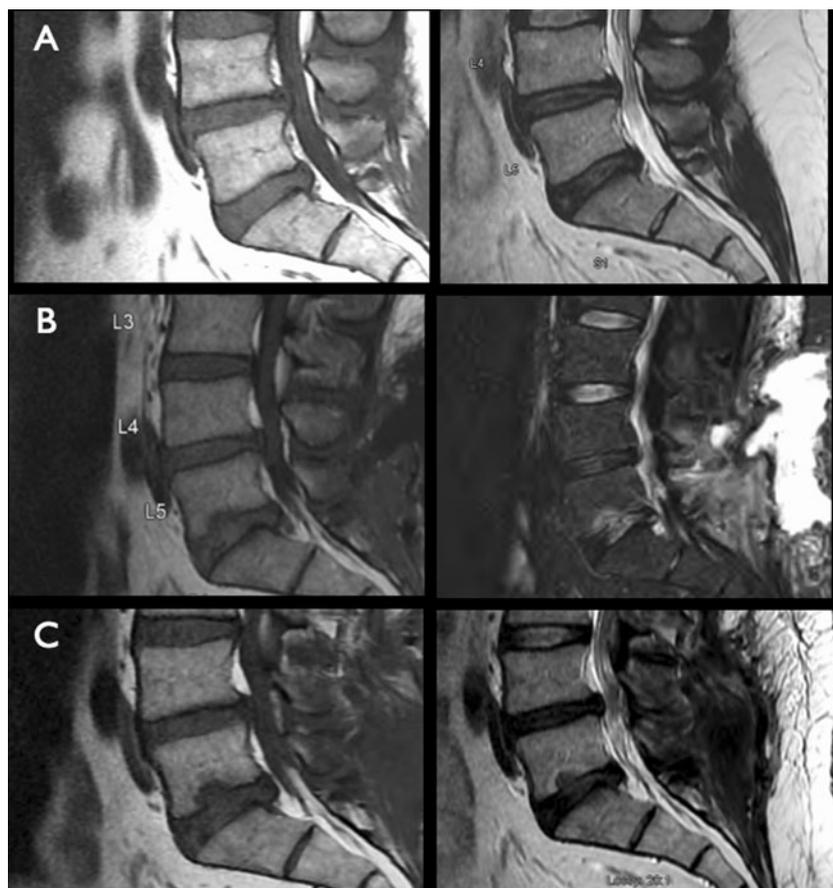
MRI of the lumbar spine demonstrating that endplate degeneration caused by traumatic external factors may lead to formation of Schmorl's nodes which may increase in size and progress with adjacent bone marrow edema. a Initial sagittal MRI (T1WI on the *left* and T2WI on the *right*) in a patient with clear left radicular pain and a L5/S1 disc protrusion. b The patient was submitted to a left L5/S1 microdiscectomy and presented complete resolution of the radicular pain. Nevertheless, 3 months later, he returned to follow-up with low back pain. The new MRI demonstrated a
